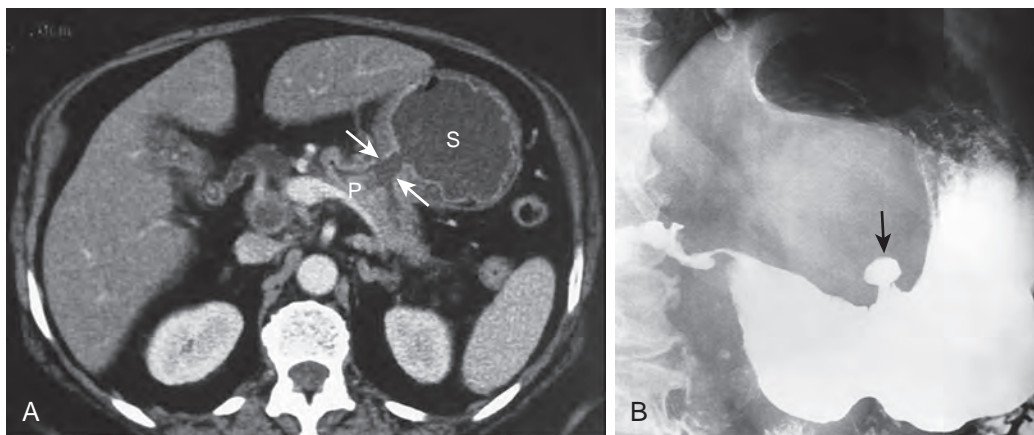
Spontaneous rupture of a pseudocyst into the stomach. A. The patient had a documented large pseudocyst scheduled to be surgically drained. CT examination before elective surgery shows decompression of the pseudocyst into the stomach (S) (arrows). P, Pancreas. B. Upper gastrointestinal examination reveals an ulceration (arrow) consistent with spontaneous drainage of a pseudocyst.
